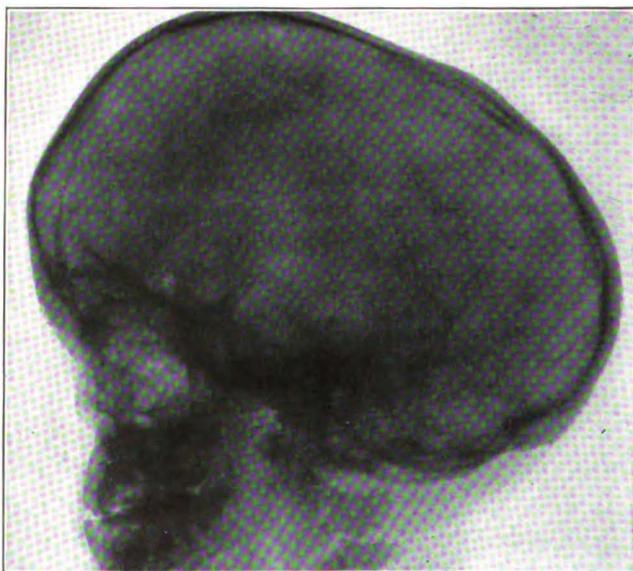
(Case 2).—Roentgenogram of profile, revealing deep sella turcica.
